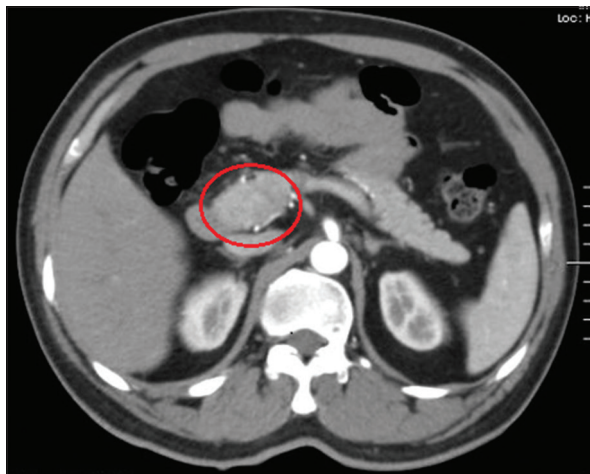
Abdomen CT scan revealed a homogeneous solid mass in the head of the pancreas
